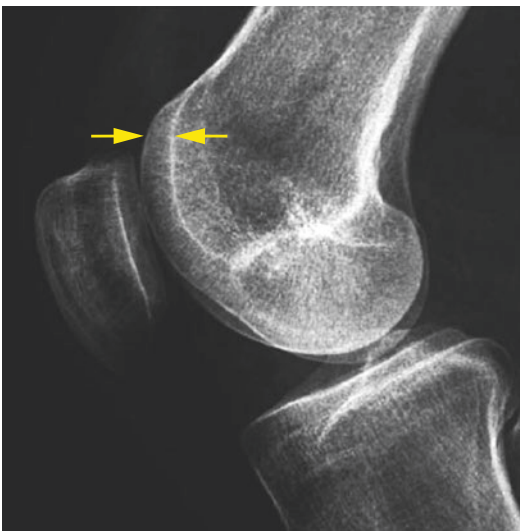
Measurement of trochlear groove depth on the lateral radiograph of the knee
